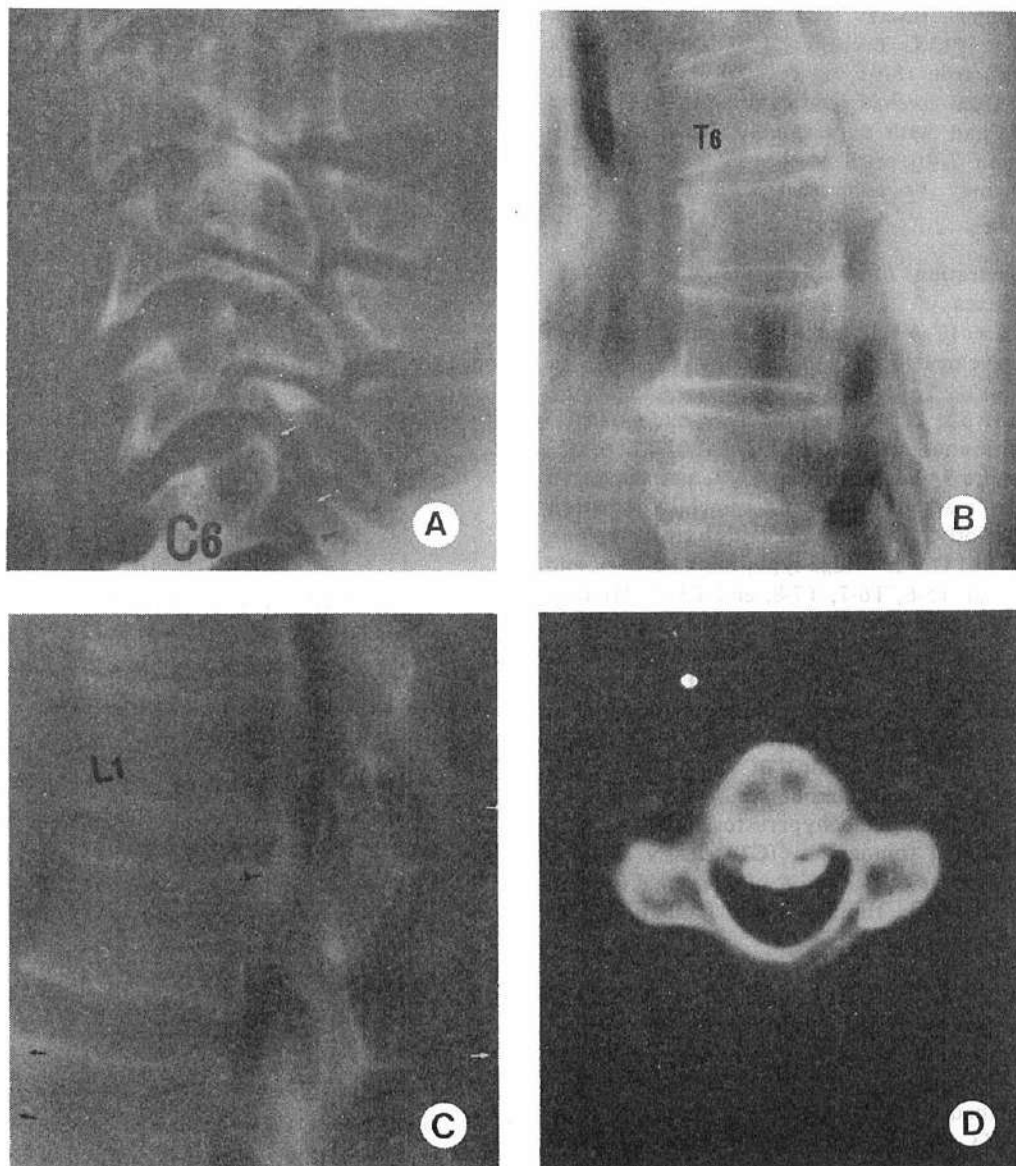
Case 32: (A) Lateral cervical spine radiograph shows continuous PLLO (arrow heads) with double PLLO plaques at C6 and C7 (arrows). Marked ankylosing spinal hyperostosis is also present. (B) Lateral thoracic tomogram shows a thick bridge-like PLLO segment at the posterior aspects of the intervertebral space at T4-5, & bridge-like PLLO segments at T5-6, T6-7, T7-8, and T8-9. Along the anterior aspect there is also a bridge of ossification (ankylosing spinal hyperostosis). (C) Lateral lumbar tomogram shows continuous linear PLLO (arrow heads) along the posterior aspects of vertebrae from T11 to L2. Ankylosing spinal hyperostosis (arrows) & ossified supraspinous ligament (arrows) are also present. (D) Computed tomography section made at the level of C2 clearly shows marked ossification of the PLLO. (E) Computed tomography section made at T5 shows ossification of the posterior longitudinal ligament and approximately 40% occlusion of the spinal canal. (F) Computed tomography section at the level of L1 shows clearly the PLLO.
